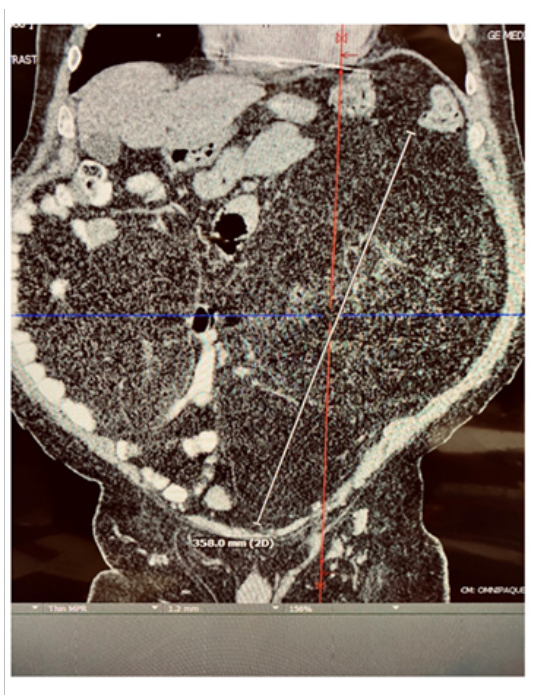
A CT scan of the pelvis.
